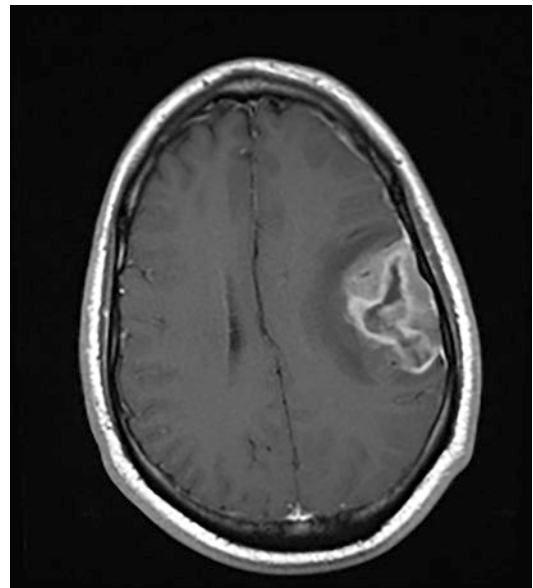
MRI scan of a primary brain tumor, a left posterior frontal glioblastoma
